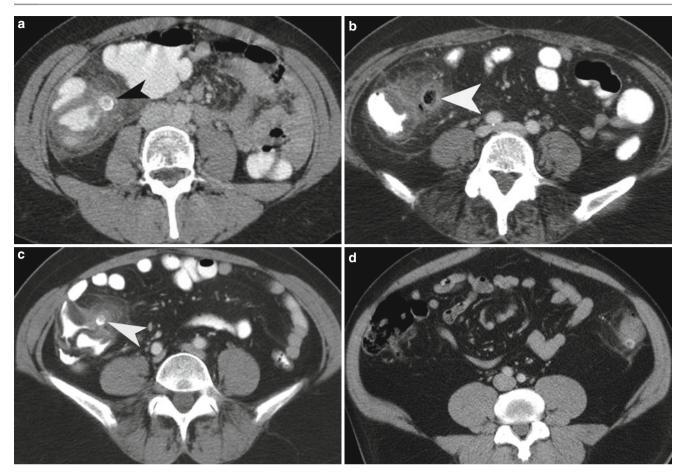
Acute diverticulitis (a-c) Contrast-enhanced CT scan study of the abdomen demonstrates inflamed diverticulum (*arrowheads*) arising from the ascending colon. There are pericolonic inflammatory changes seen around the inflamed colonic diverticulum. (d) Contrast-enhanced
